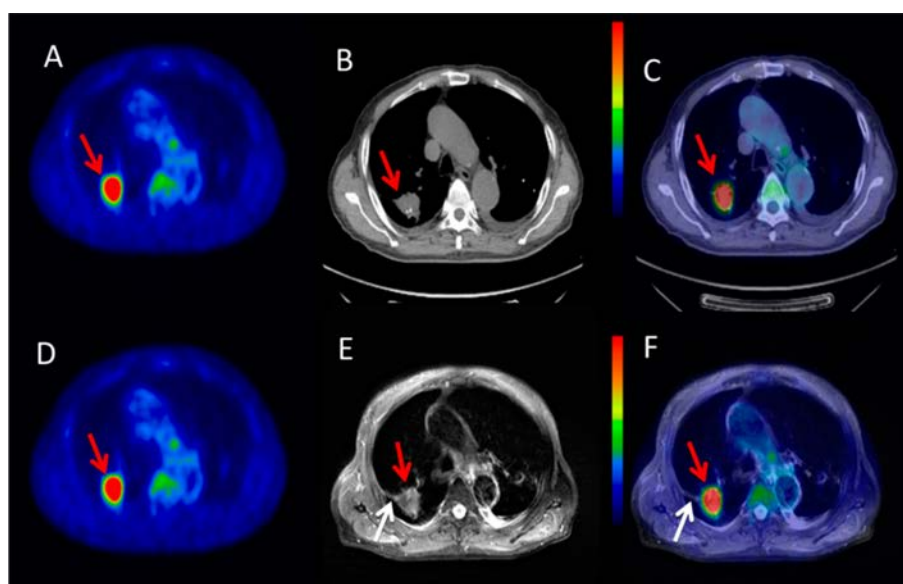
Images for a 58-year-old female with lung cancer confirmed by pathology. ^{18}F -FDG uptake was observed in PET images (A and D); both CT (B) and T_2 -weighted MRI (T2MRI) (E) showed the main lesion (red arrow). However, only T2MRI (E) showed the pleural retraction accompanied by lung cancer (white arrow). PET/CT (C) showed only the main lesion, while PET/MR (F) showed both the main lesion and the pleural retraction.
